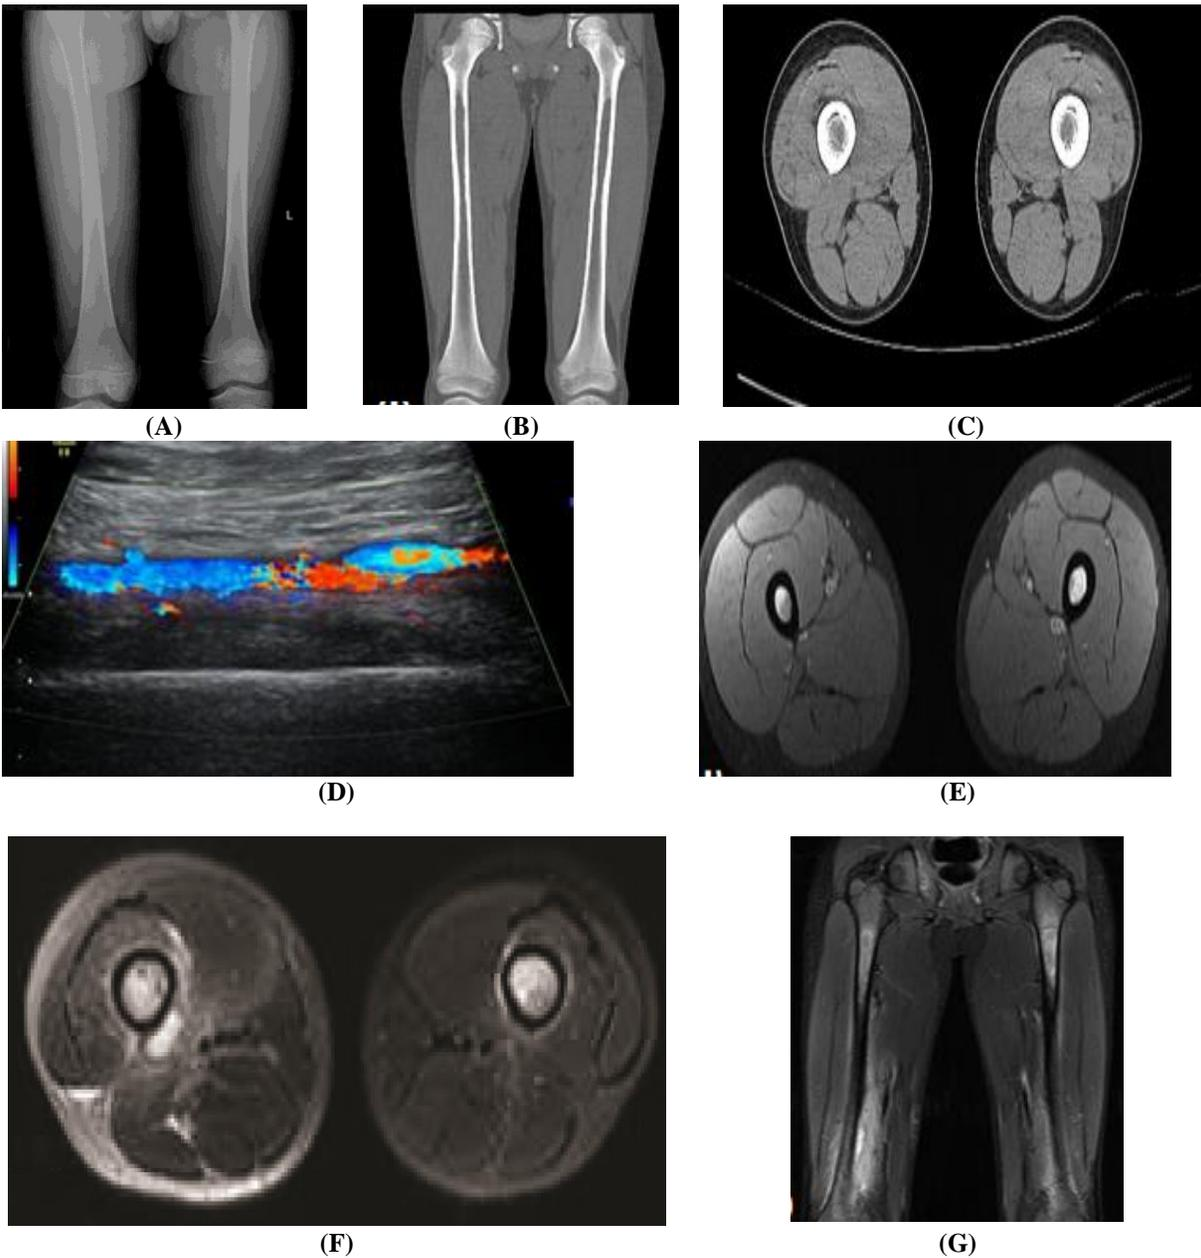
10 years old boy complaining of bilateral thigh pain swelling and tenderness more at the right side. (A) Radiography of both femurs AP view shows no detectable abnormality. (B&C) Coronal reformatted CT of both femur (bone window)and axial bone soft tissue window respectively demonstrate no defined abnormality (D) Colour Doppler high resolution US longitudinal view show juxta-cortical thin layer of turbid collection with Juxta cortical circumferential soft tissue hyperemia. (E) MRI axial STIR (F) Axial T1 fat suppression with IV contrast demonstrate & (G) Coronal STIR demonstrate Diffuse bilateral femoral meta-diaphyseal abnormal heterogeneous bone marrow signal intensity predominantly high at STAIR and exhibit patchy contrast enhancement
